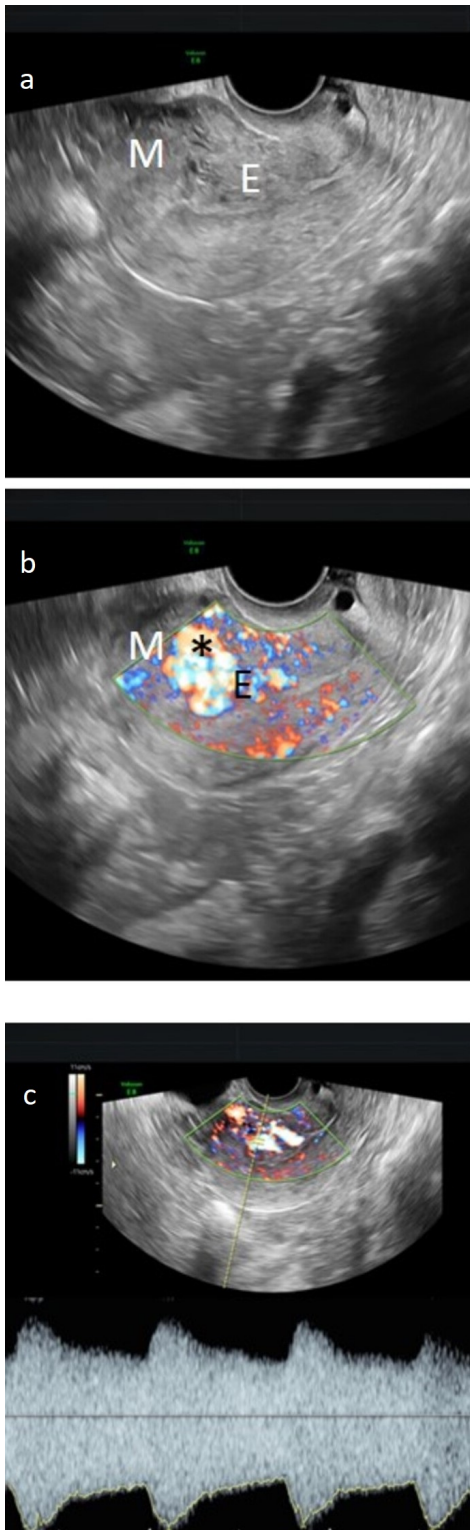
Transvaginal ultrasound of Patient 8, sagittal plane of the uterus. (a) Gray scale ultrasound image shows inhomogeneous endometrium (E) and irregular myometrium (M). (b) Power Doppler reveals enhanced myometrial vascularity with multidirectional flow (asterisk). (c) Spectral Doppler shows low-resistance flow with PSV = 73 cm/sec.
